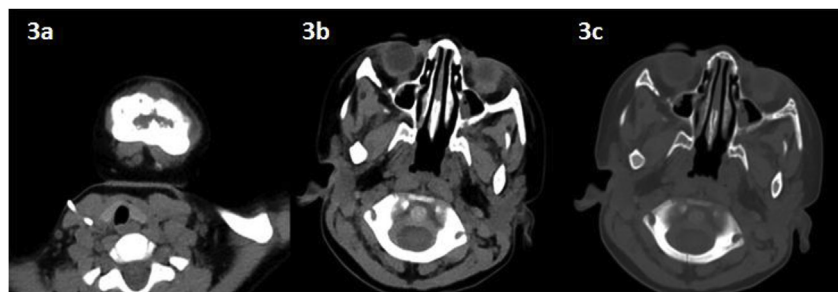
CT images after five chemotherapy cycles. 3a The mass in chin shrunk to approximately 1.0 cm × 0.7 cm 3b The mass in left maxillary sinus vanished. 3c Destruction of mandibular bones get less in size.
